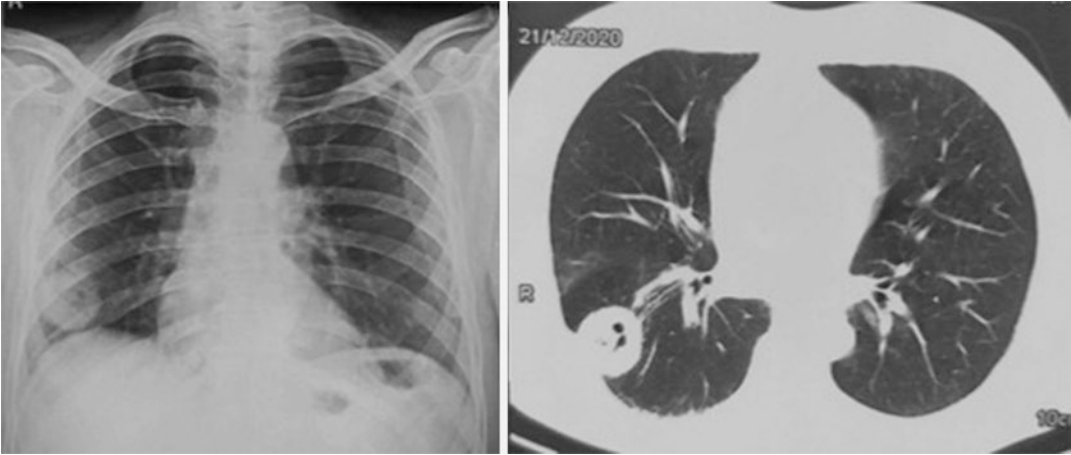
Chest X-ray PA view (left panel) showing a nodular opacity in the right lower zone. CT scan showed a thick-walled lesion with central cavitation. Biopsy was suggestive of pulmonary Aspergillosis
